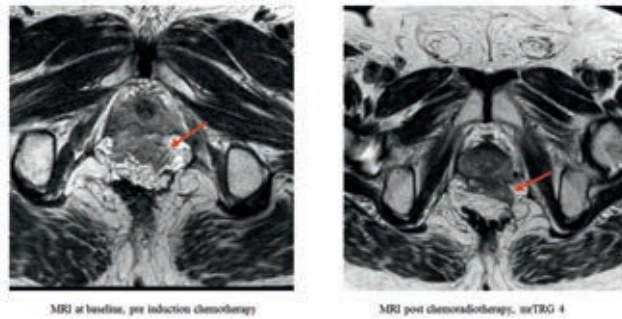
MRI at baseline and post chemoradiotherapy showing a slight radiological response (i.e. mrTRG 4). In this case, restaging was performed > 7 weeks
